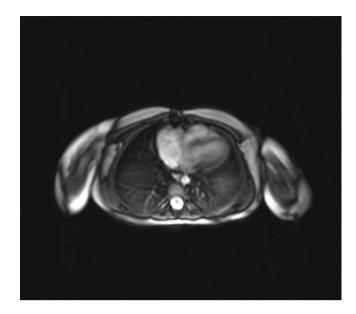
Cardiac MRI 6 months after tumor resection that showed no residual mass.
